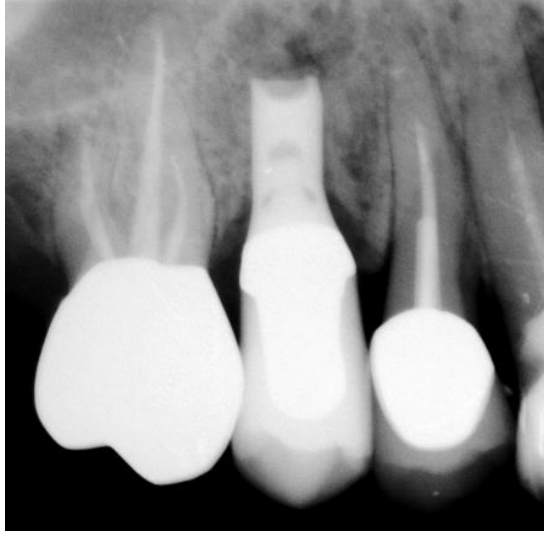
Radiograph taken two years after implant resection. Note the nearly complete new bone formation.
